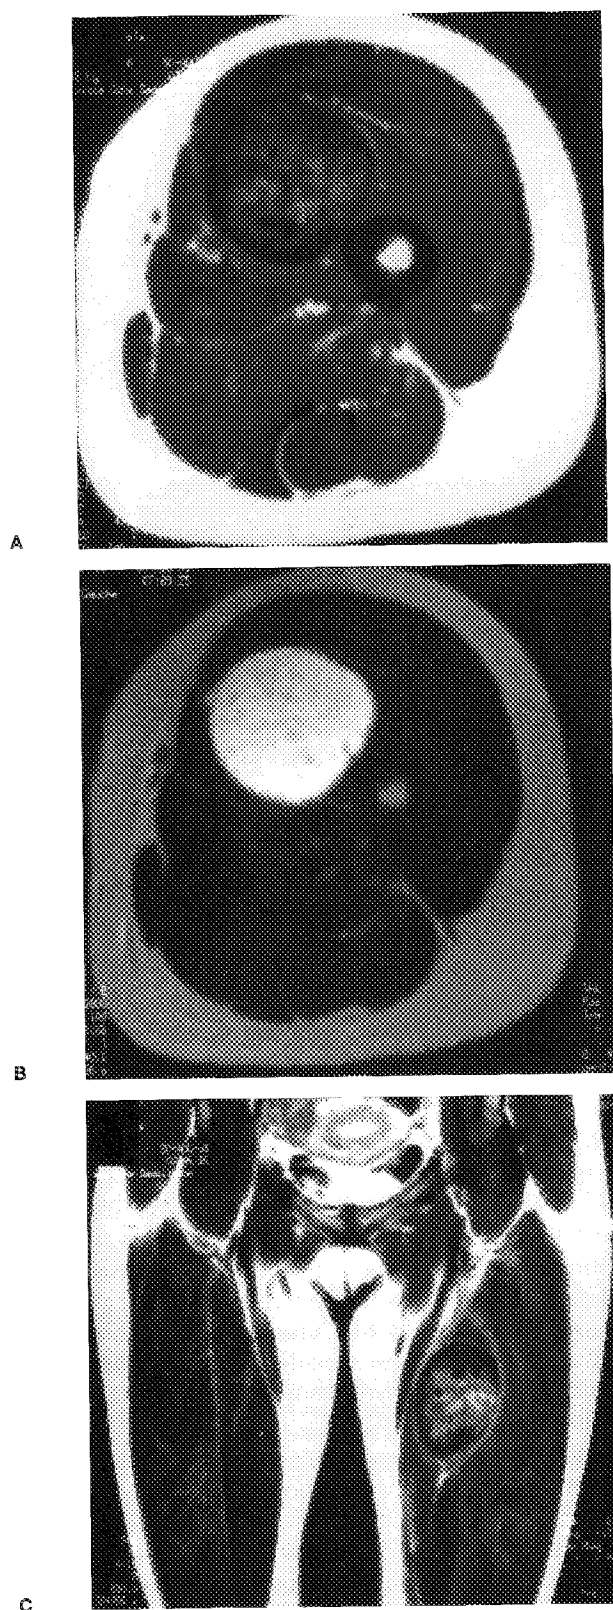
Magnetic resonance imaging of the left thigh. A: T1-weighted sequence after gadolinium injection, transversal section; B: T2-weighted sequence, transversal section. C: T1-weighted sequence after gadolinium injection, coronal section.
